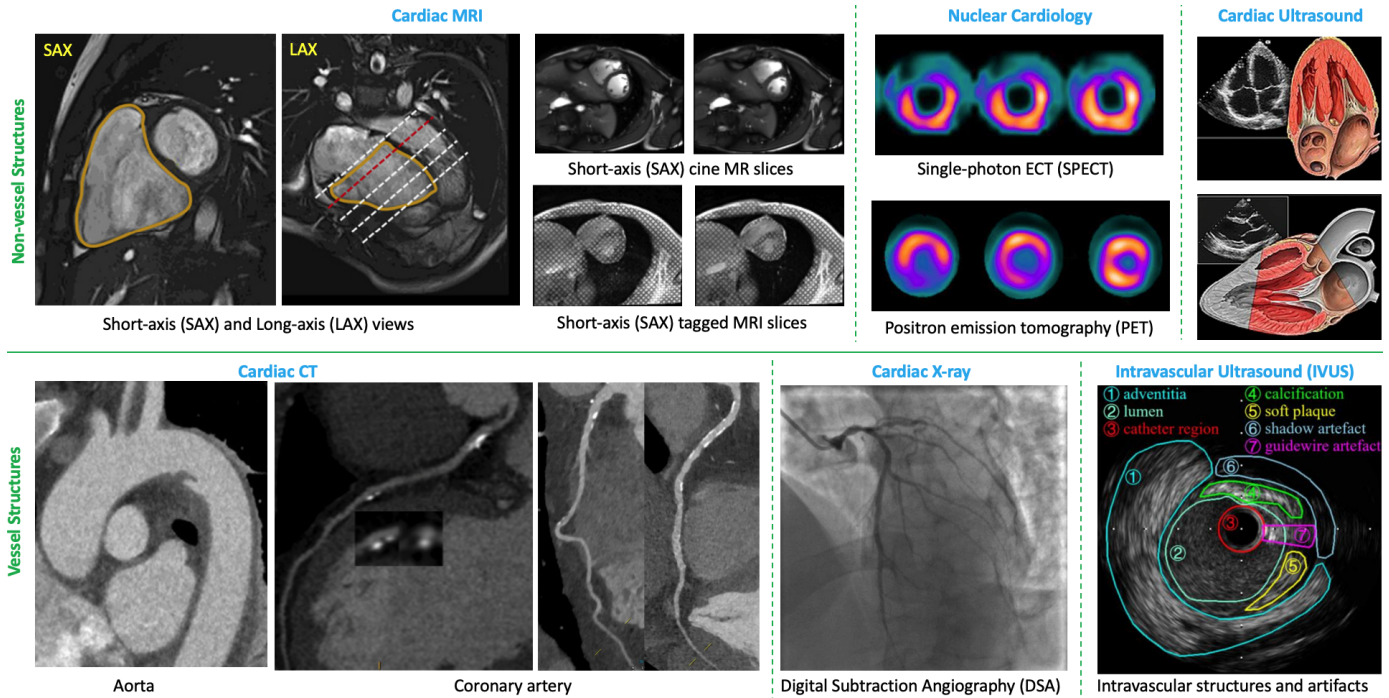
Examples of Cardiac Data Modalities. Top (Non-vessel): Cardiac MRI [29], Cine MRI and Tagged Cine MRI [30], Nuclear Cardiology [31], Cardiac Ultrasound [32]. Bottom (Vessel): Cardiac CT (Aorta [33], Coronary [34], [35]), Cardiac X-ray [36], Intravascular Ultrasound (IVUS) [37].
